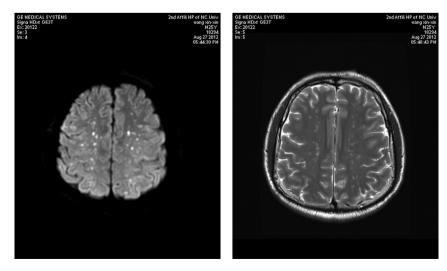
Head MRI showed long T₁ and T₂ signals with diffuse punctuates, and high signal intensity on DWI throughout bilateral cerebral cortex, white matter, basal ganglion, thalamus and brainstem.
